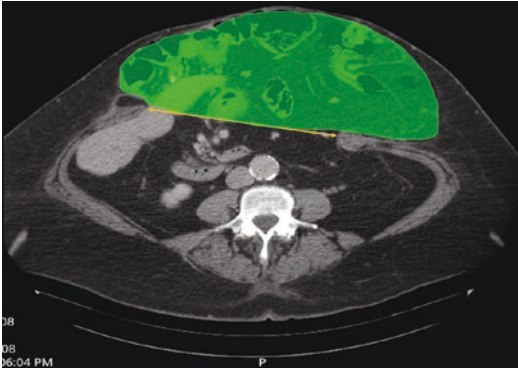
Computed tomographic image showing axial measurements obtained using the TeraRecon, Inc., software. Defect size (transverse) is indicated by the yellow arrow and defect area highlighted in green. Adapted from Franklin et al. [62]
